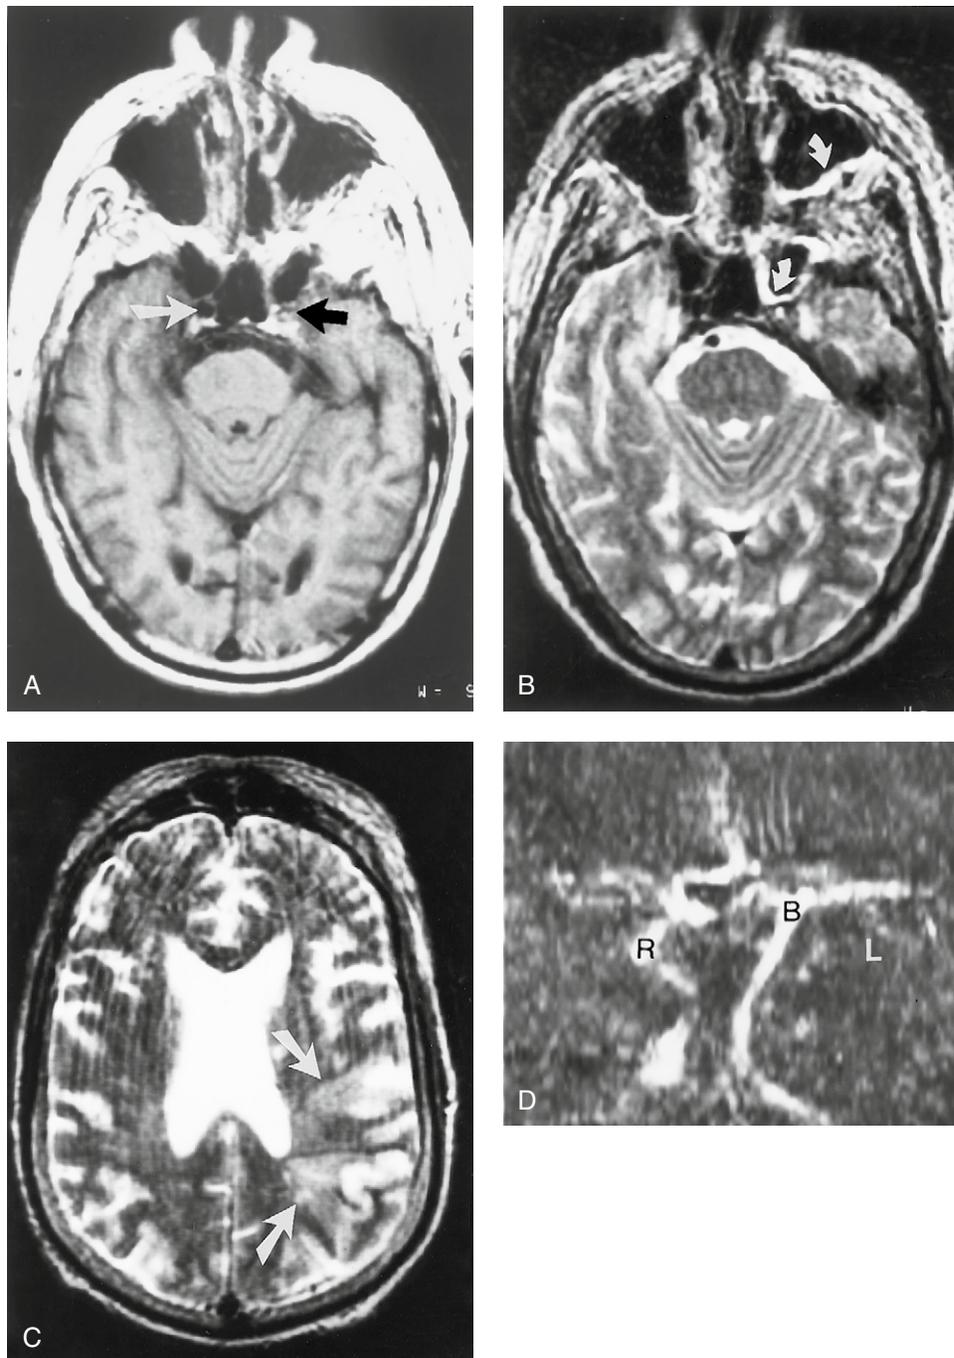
Rhinocerebral zygomycosis with occluded internal carotid artery and multiple infarcts. (A) Axial T1-weighted image shows normal signal void of the right internal carotid artery (white arrow) and abnormal increased signal within the occluded left internal carotid artery (black arrow). (B) Axial T2-weighted images shows hyperintense mucosal thickening of the left maxillary and sphenoid sinuses (small white curved arrows). (C) Axial T2-weighted image shows wedge shaped hyperintense infarcts in the left posterior temporal-parietal region (white arrows). (D) Frontal view from a 3D time of flight MR angiogram shows normal flow, bright signal, in the right internal carotid artery (black "R") and basilar artery (black "B"). No flow is detected in the expected location of the left internal carotid artery (white "L").
